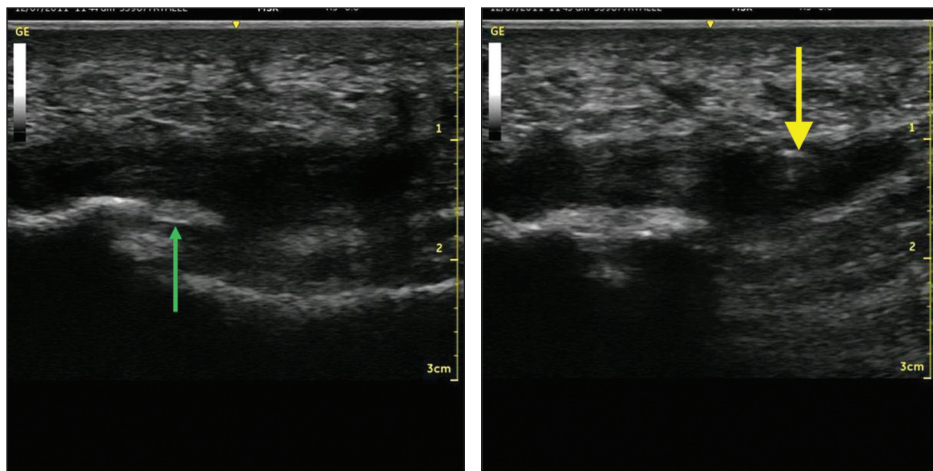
Ultrasound image demonstrates thickening of the plantar fascia (green arrow) with concomitant heel spur. The needle is perpendicular to the long axis of the ultrasound probe (yellow arrow).
